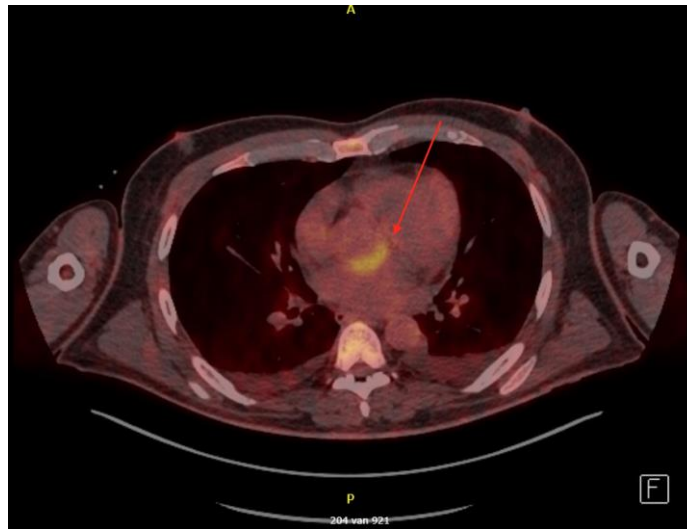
PET-CT showing findings suggestive of endocarditis at the posterior part of the aortic valve
